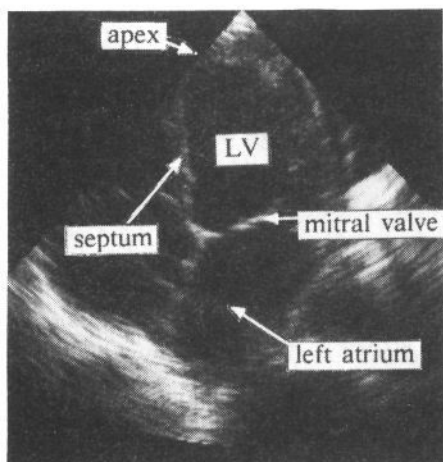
a : An apical 4-chamber echocardiogram
